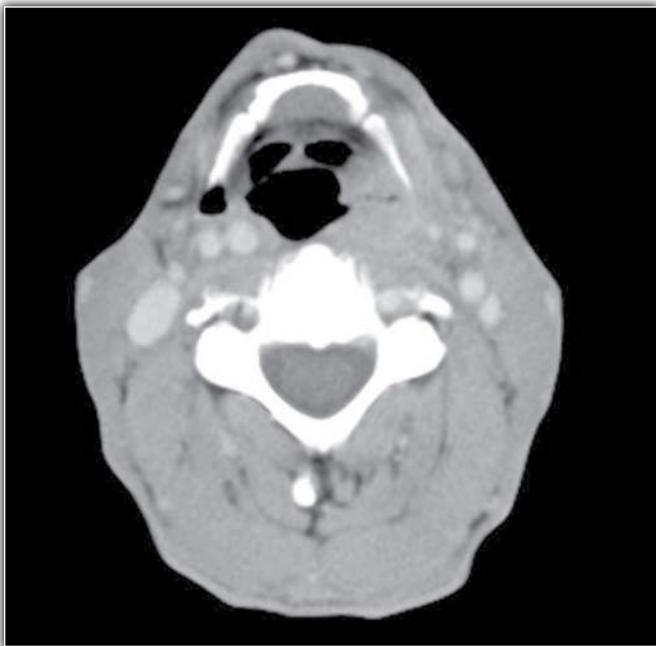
and B Axial contrast enhanced CT scan at the level of hyoid bone (A) and at the level of atlas vertebra (B) shows multiple hypodense lymph nodes along the jugular chain—tubercular lymphadenitis
